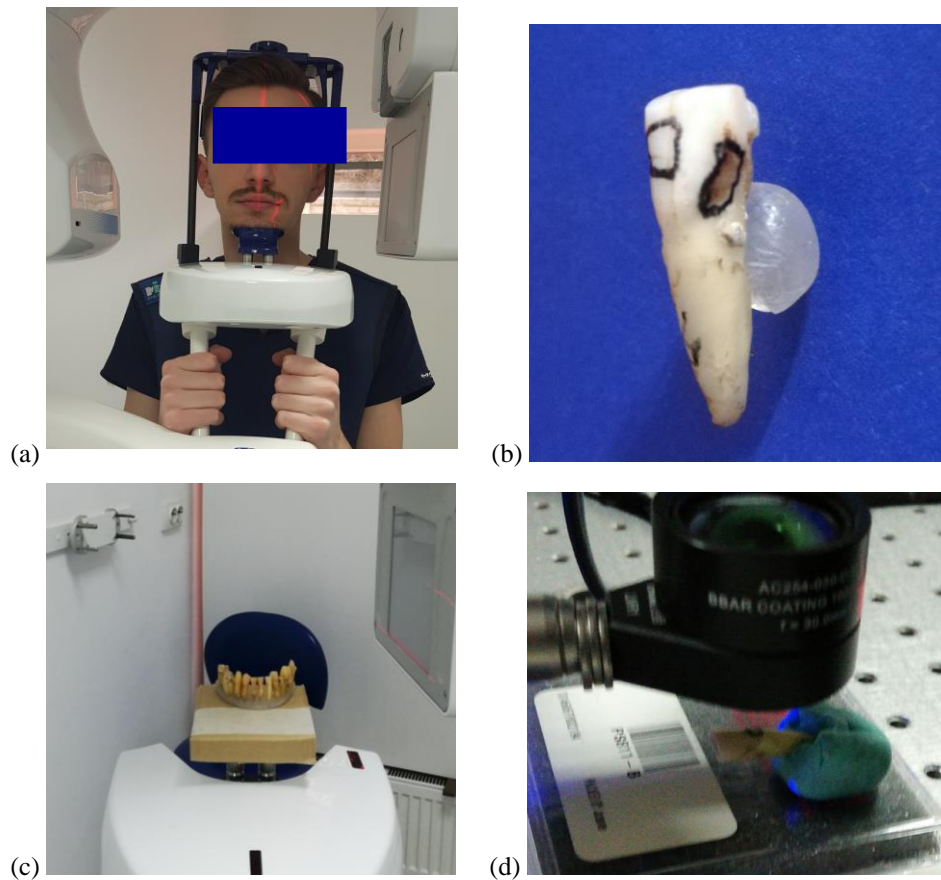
Steps from the protocol of the study: (a) X-rays diagnose; (b) tooth extraction and preparation for further investigations; (c) *ex-vivo* X-ray investigations; (d) OCT investigations.
